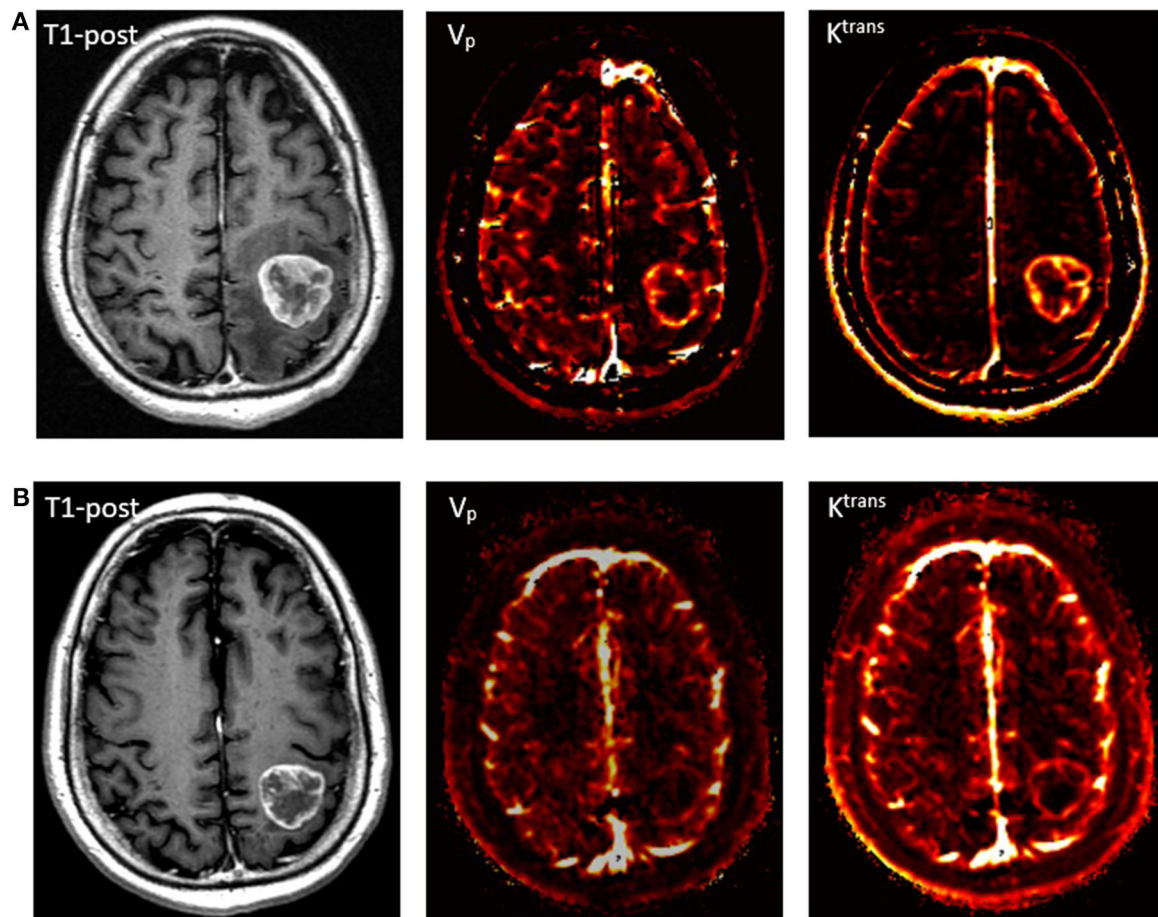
Perfusion imaging of a patient with metastatic squamous cell carcinoma. (A) A pre-treatment T1-post contrast MRI with corresponding V_p and K^{trans} perfusion imaging demonstrating increased signal. (B) 2-month follow-up scan after receiving SRS with 27 Gy in 3 fractions showing slight contraction of the mass on T1-post MRI and marked decrease in perfusion.
